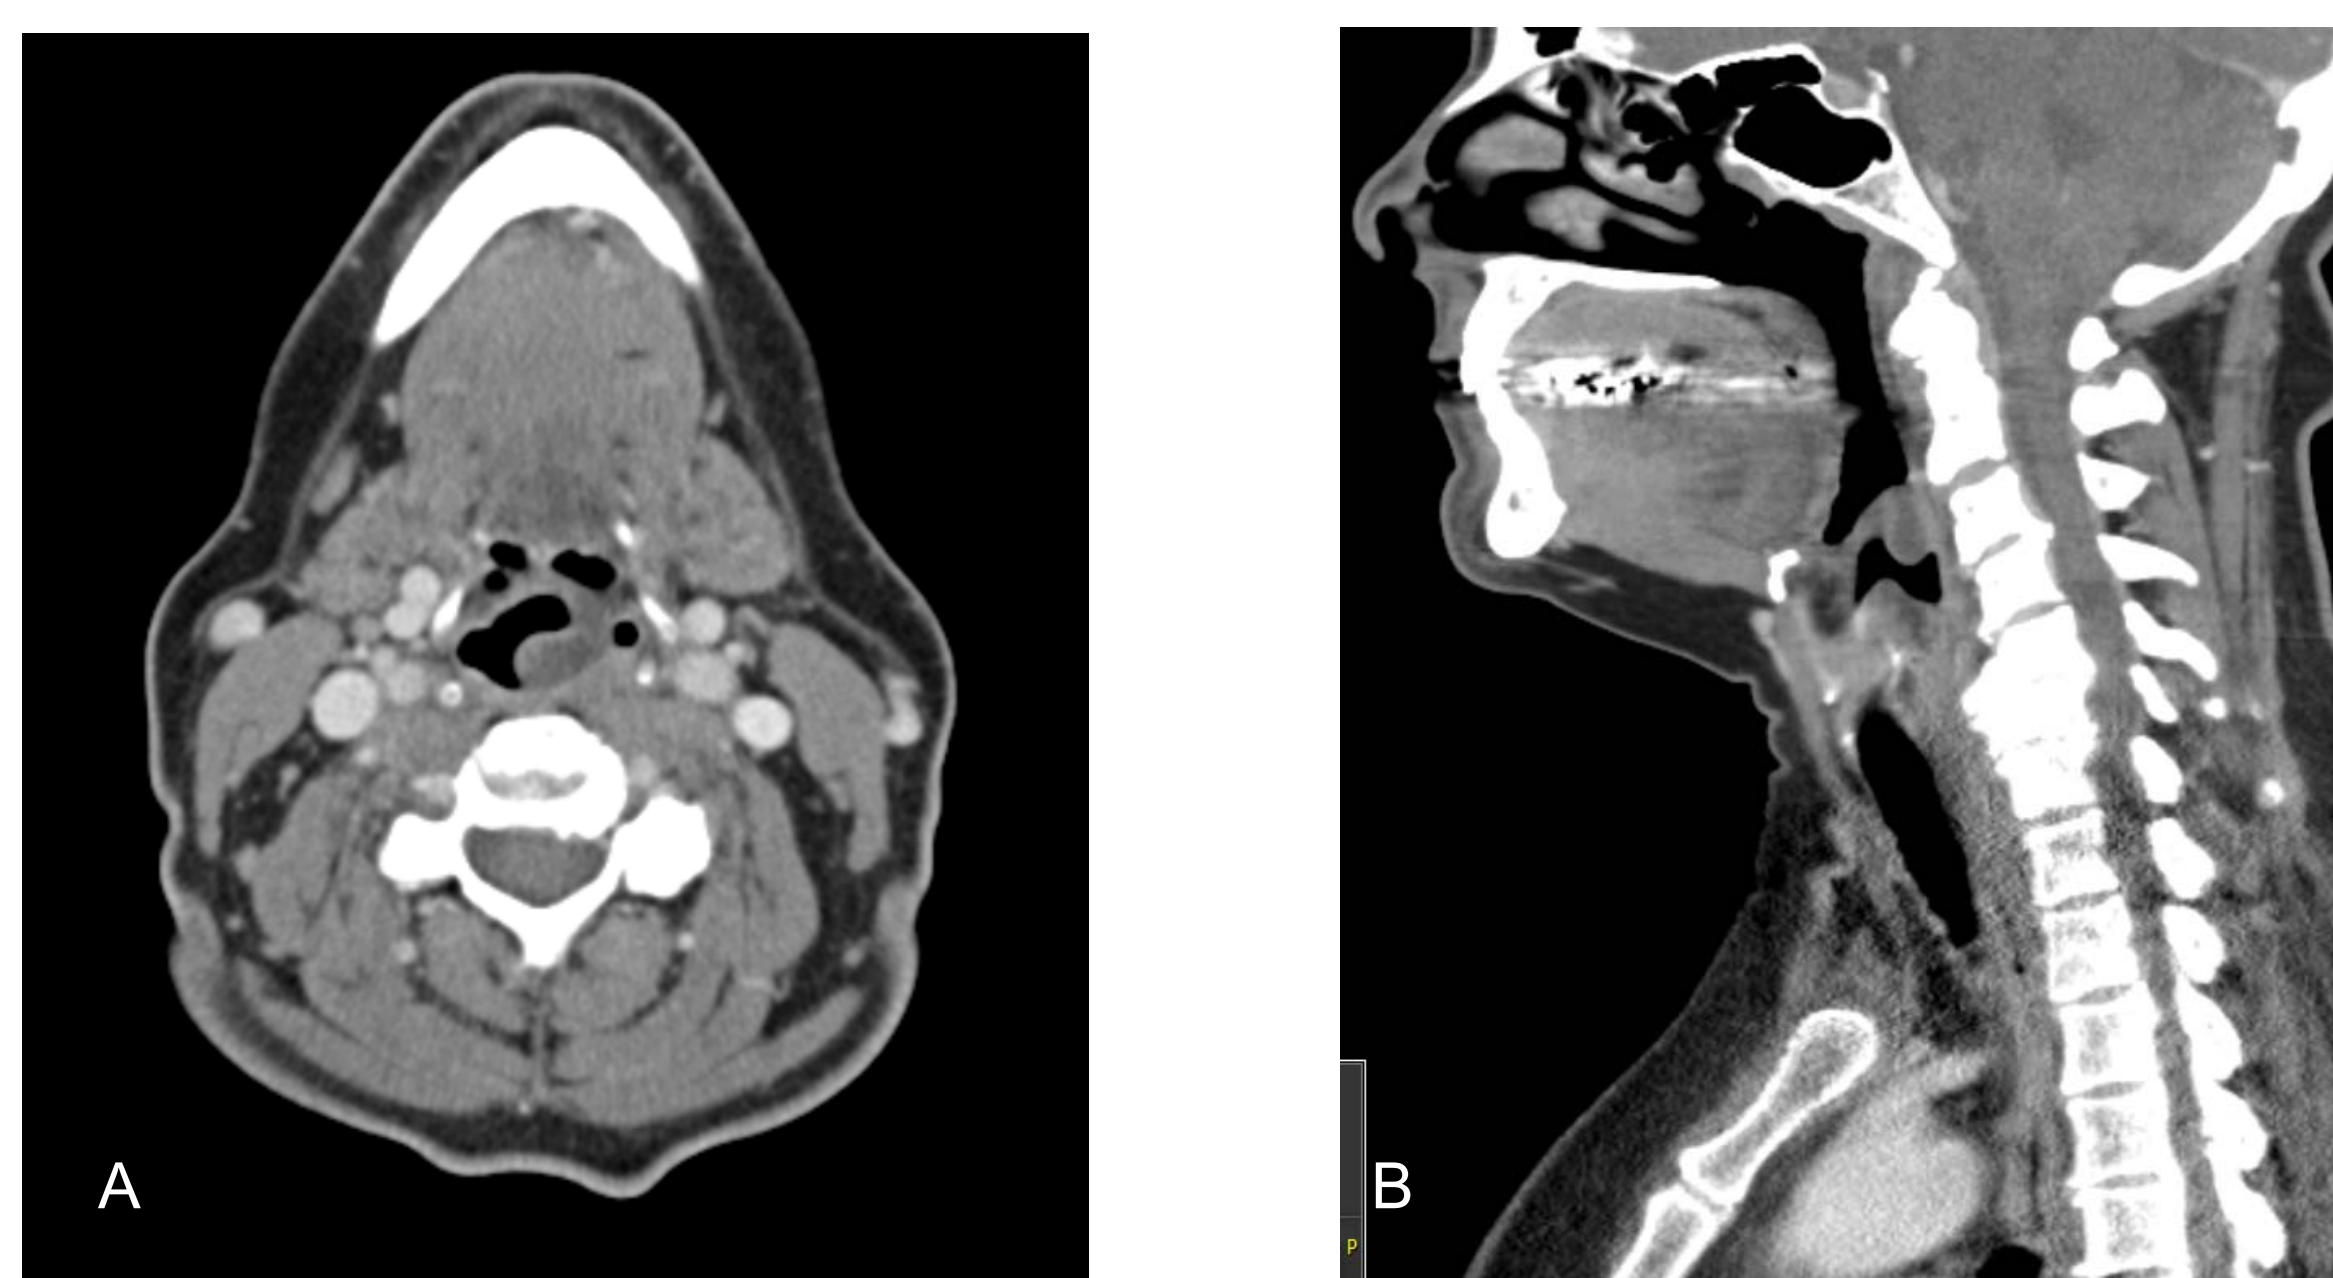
Contrast-enhanced axial (A) and sagittal (B) CT images demonstrating an approximately 1.8 x 1.6 x 1.3 cm cystic mass pedicled on the epiglottis and left aryepiglottic fold
